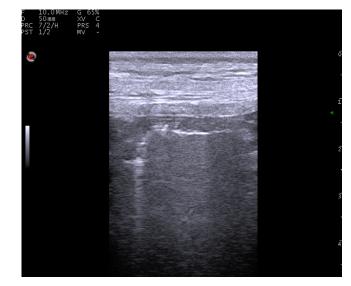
Longitudinal ultrasonographic appearance of the right cranial part of the abdomen at the gastropexy site 4 days after incisional gastropexy. The stomach wall is thicker than normal and hypoechoic; its serosal surface cannot be distinguished from that of the abdominal wall.
